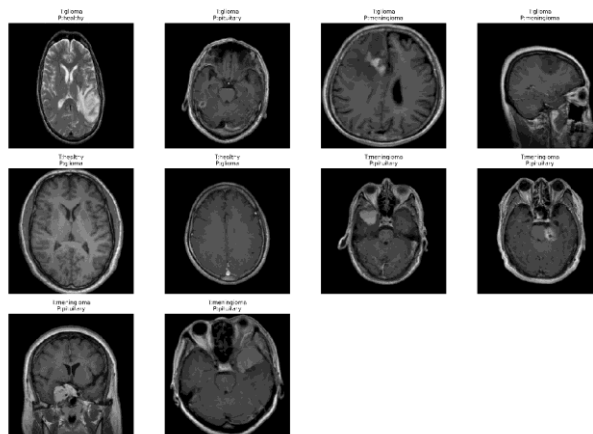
ResNet50 Misclassified MRI Images Results.
